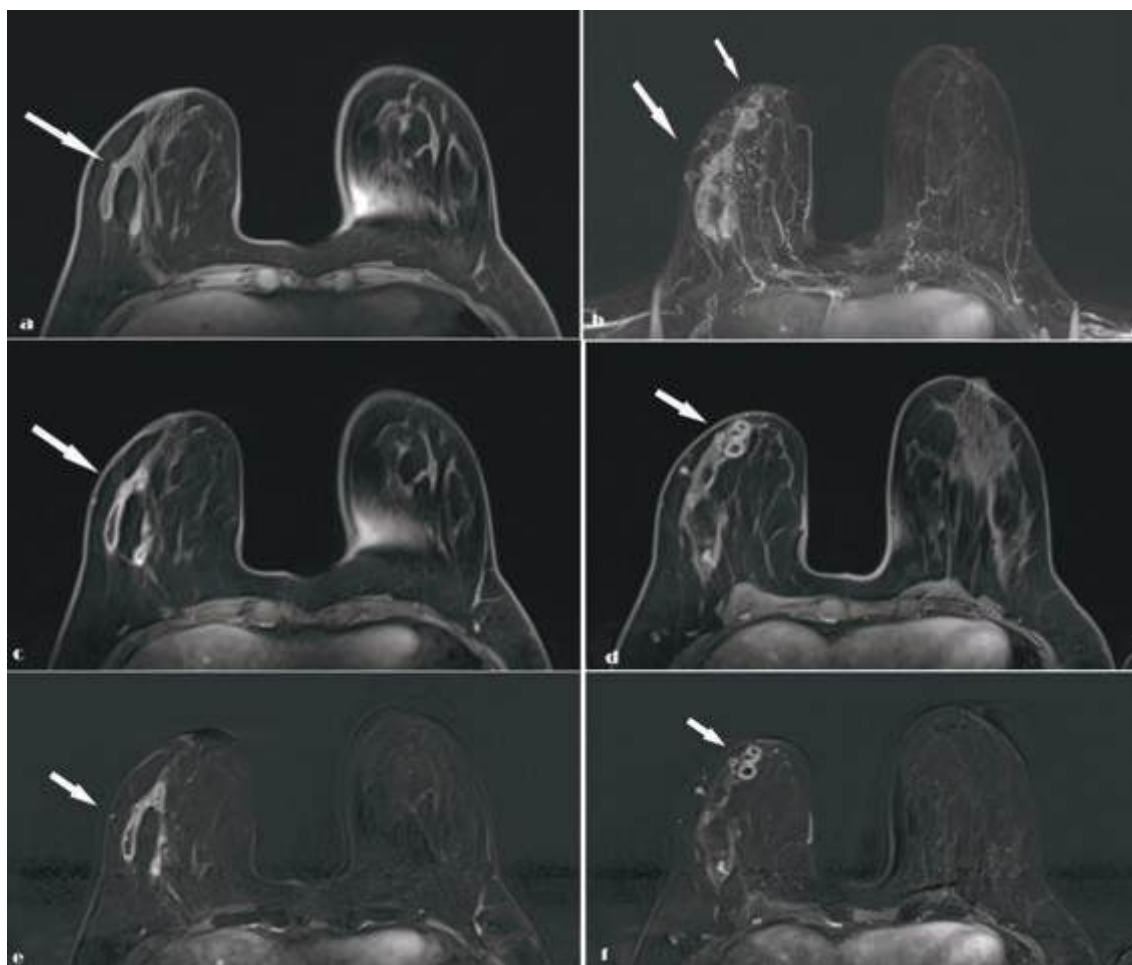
Contrast-enhanced breast MRI demonstrating multicentric abscesses in the right breast.
